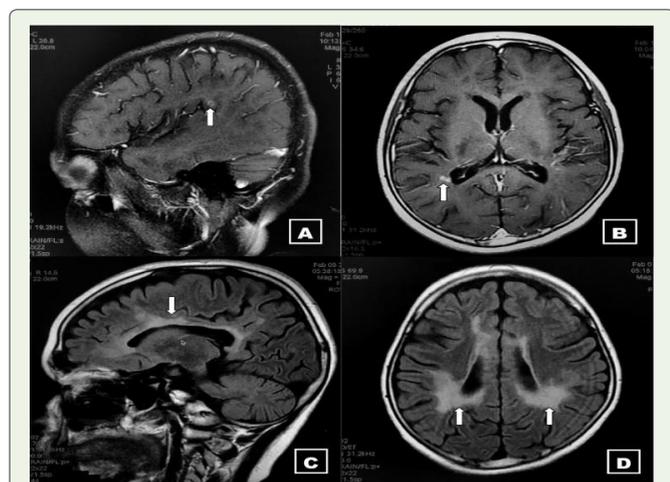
MRI Brain dated February 2021.
